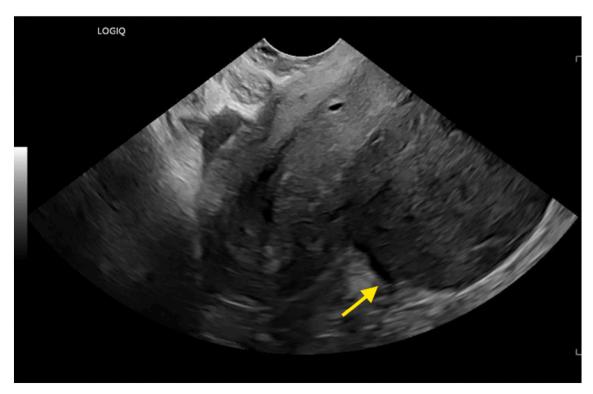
Transvaginal ultrasound sagittal view of the uterus and posterior-cul-de sac demonstrating 8.9 cm echogenic mass arising from the pelvic midline.
